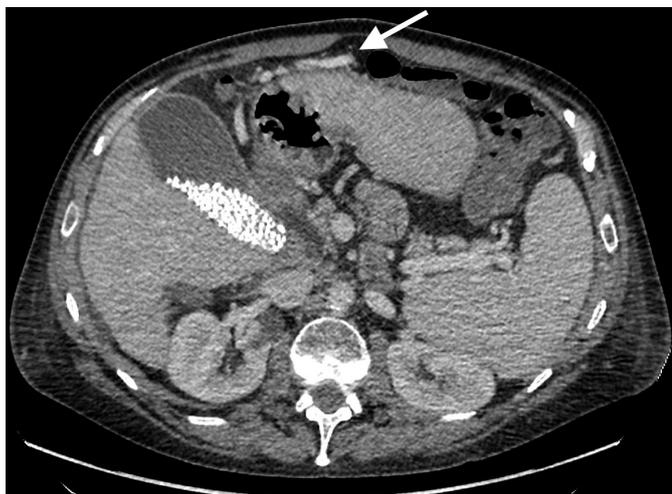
CT scan (portal phase) showing microlithiasis and recanalised umbilical vein (arrow). No signs of gallbladder varices or chronic cholecystitis are evident.
